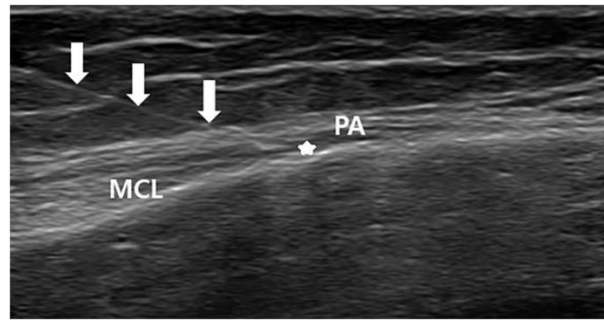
US-guided injection, longitudinal ultrasound image of a needle (white arrow) in the PA bursa (asterisk) between the medial collateral ligament (MCL) and the PA tendon. Retrieved from: Lee JH, Lee JU, Yoo SW. Accuracy and efficacy of ultrasound-guided pes anserinus bursa injection. *J Clin Ultrasound.* 2019 Feb;47(2):77-82.
